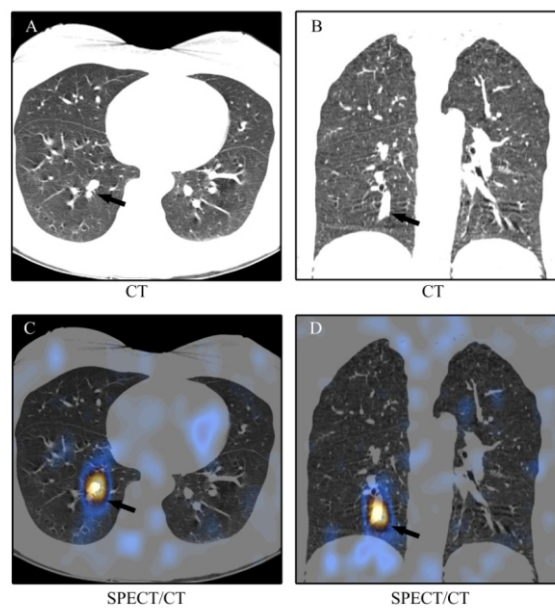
CT (A, B) and SPECT/CT (C, D) localized the activity to the pulmonary vasculature of the basal segment of the right lower lobe (arrows). CT demonstrated no abnormal density shadow. The thyroglobulin level was 18.64ng/mL, the TgAb >500u/mL, the TSH >150uIU/mL, and the patient had no complaint related to her lung.
